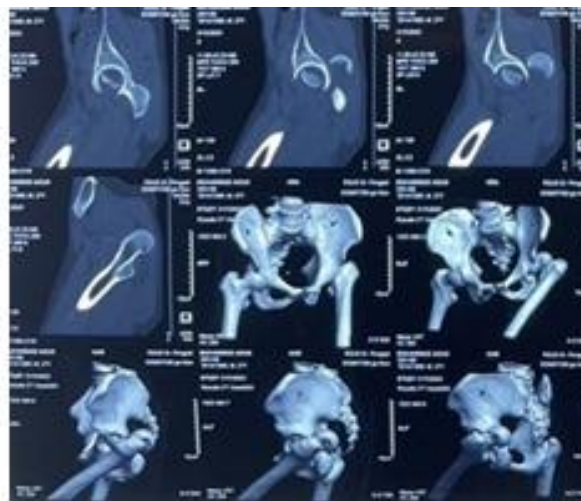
CT Scan of the pelvic result of discontinuity of left femoral head and posterior hip dislocation
